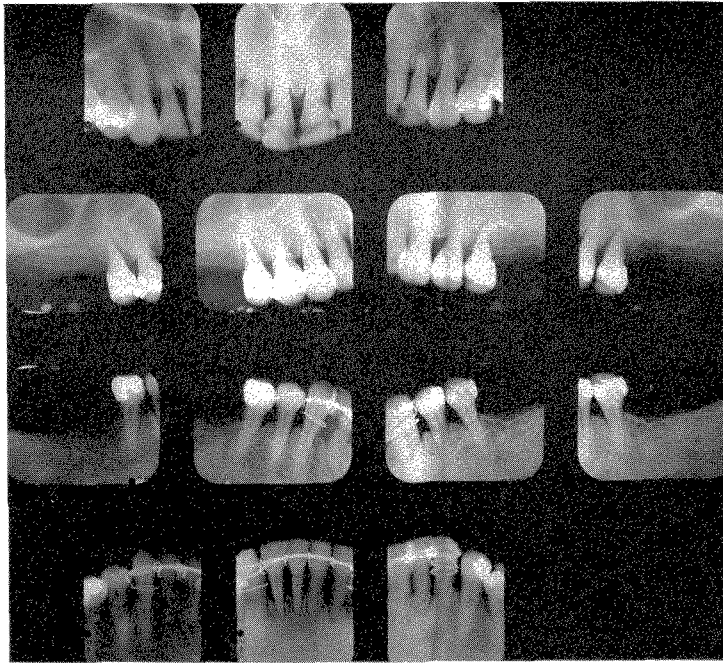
Roentgenograms taken in 1956 at the start of treatment.
